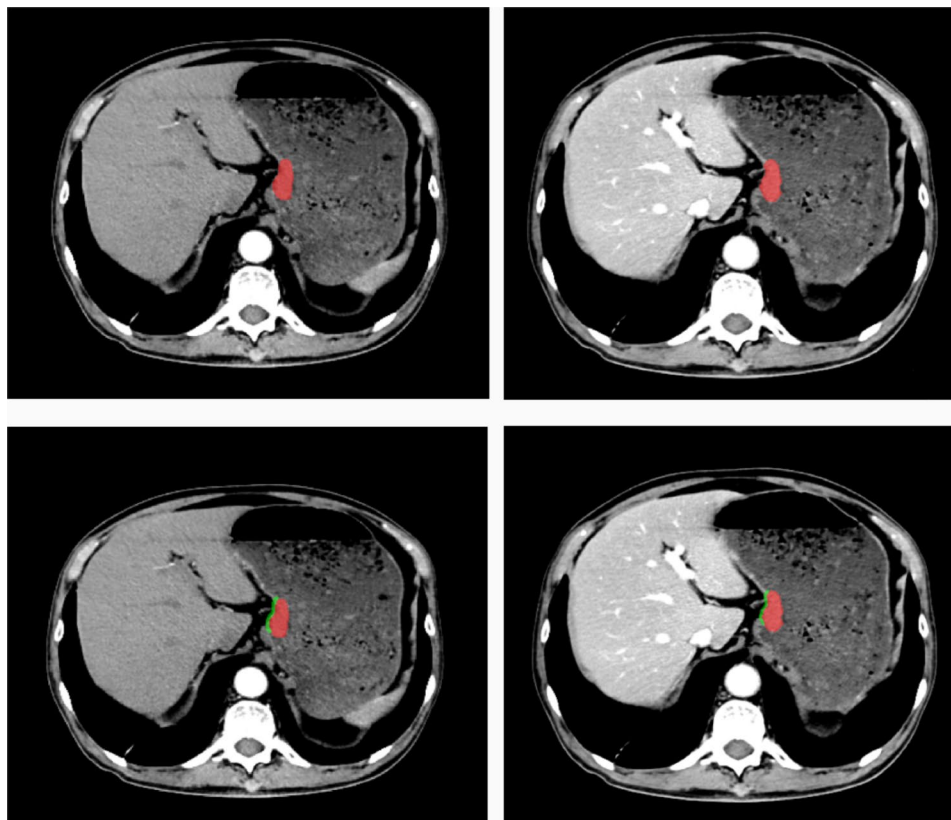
Lesion segmentation of a typical gastric cancer on dual-phase contrast-enhanced CT images
